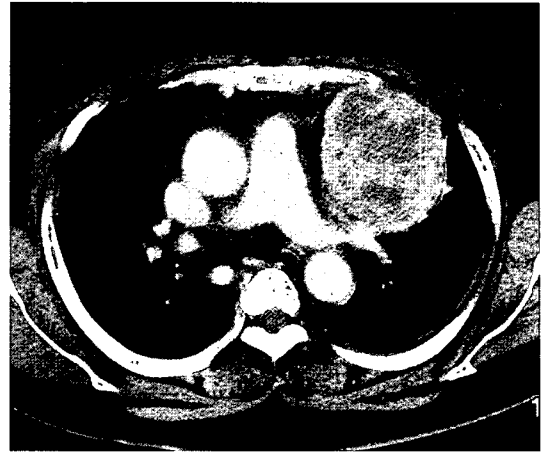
Chest CT finding. It reveals 10 x 9 x 5.5 cm sized solid and heterogeneous mass with multiple lymphadenopathy. The mass is located in the anterior mediastinum and attached to the aortic arch, pericardium, and anterior chest wall.
